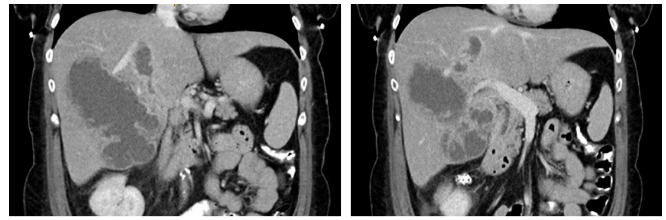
Computed tomography images of a 64-year-old type II diabetic male with symptoms of biliary colic and intermittent fevers who returned from travel in South America 8 weeks earlier. Stool and serum studies were negative for *E. histolytica*. He underwent laparoscopic drainage of the abscess and cholecystectomy, and was discharged home on postoperative day 3. He received antibiotics for 2 weeks and the drain was removed on postoperative day 7.
